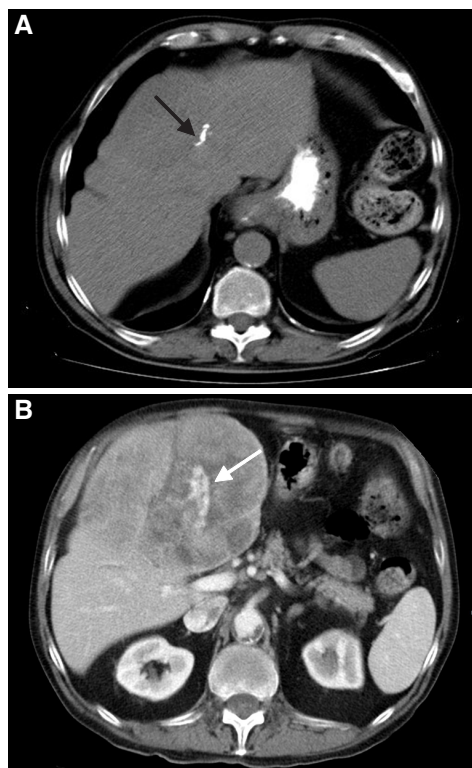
Computed tomography of axial planes in empty (A) and portal phase (B). Liver mass in non-cirrhotic liver with calcifications (black arrow) and important vascular component (white arrow)
